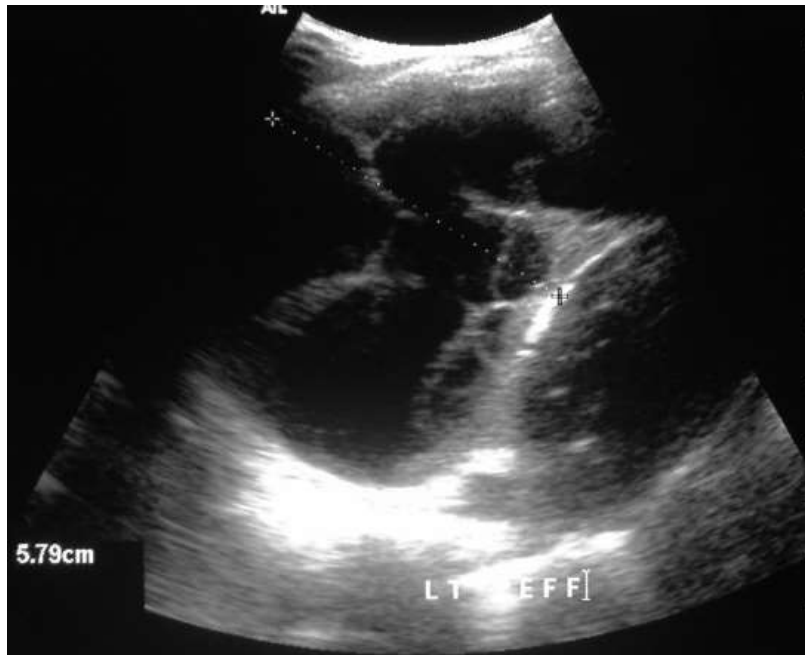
Ultrasound shows stage 2 parapneumonic effusion. Pigtail drain was introduced and fibrinolysis agent was given.
